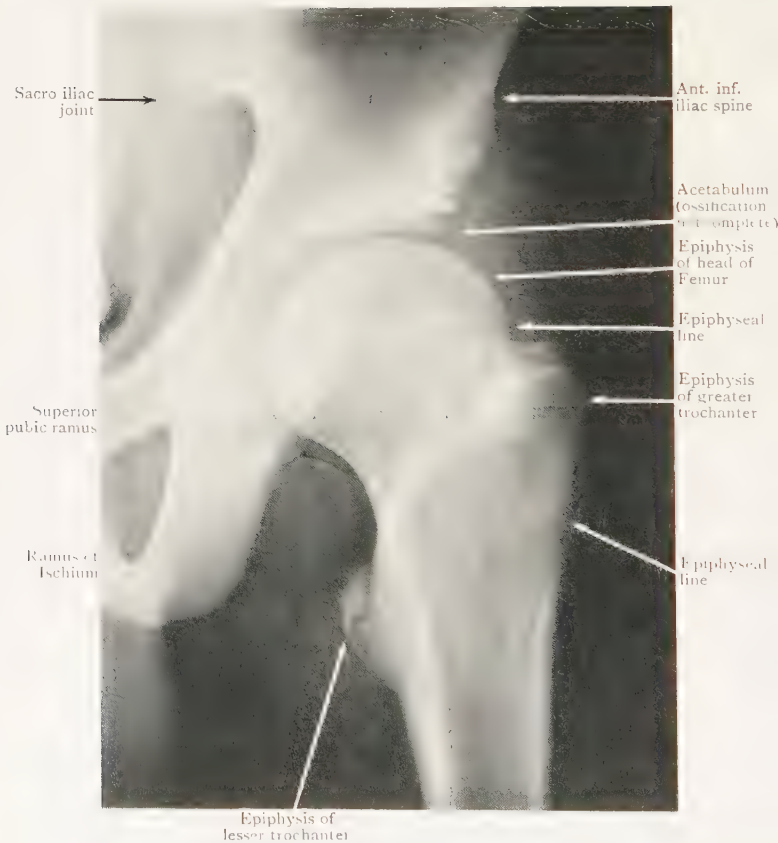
Anteroposterior Radiograph, Hip of boy aged 14.
